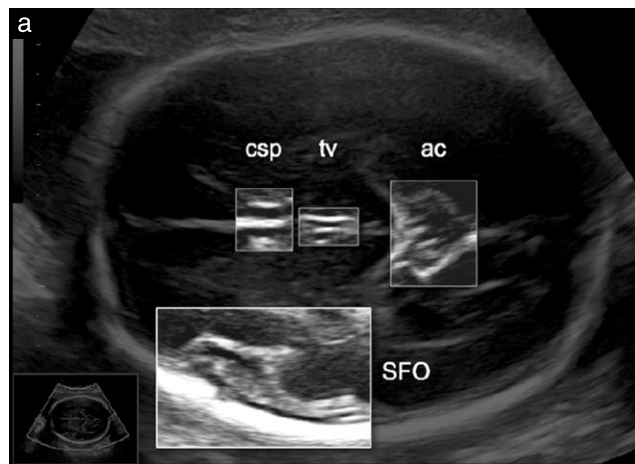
(a) Standardization of the ultrasound assessment of fetal Sylvian fissure operculization (SFO) using an axial view of the fetal brain defined by three anatomical landmarks: ambient cysterna (ac), third ventricle (tv) and the inferior part of the cavum septi pellucidi at the level of the fornix columns (csp). (b) Scoring-sheet: semiquantitative assessment of the overriding of the insula by the temporal lobe, using a scale ranking from 0 to 10. Horizontal lines represent the orientation of the insula. For Scores 0, 1 and 2, the angle between the insula and the temporal lobe is indicated, while for scores 3–10, curved lines represent the temporal lobe overriding the posterior half of the insula (Score 4 = posterior half of insula is 1/4 overridden; Score 6 = 1/2 overridden; Score 8 = 3/4 overridden; Score 10 = entirely overridden). Sc, score; US, ultrasound evaluation of SFO.
